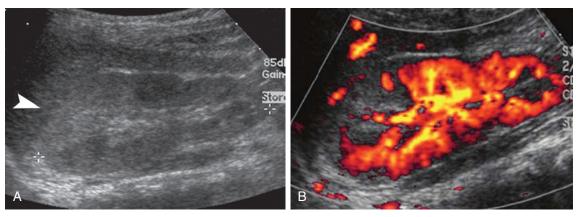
Acute bacterial pyelonephritis. A, Ultrasound (US) scan shows a wedge-shaped hyperechoic focus (arrowhead) in the upper pole of the right kidney related to acute bacterial pyelonephritis. B, Color flow US image demonstrates diminished flow through the involved area. (From Craig WD, Wagner BJ, Travis MD: Pyelonephritis: Radiologic–pathologic review, Radiographics 28:255-276, 2008.)
